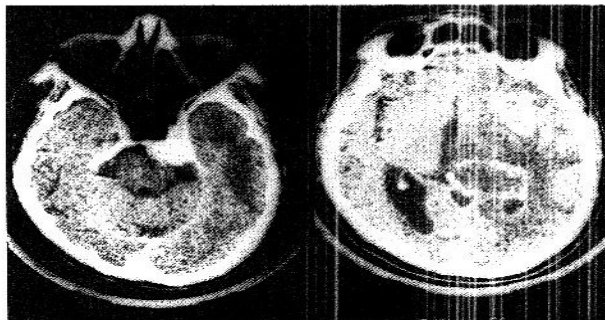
Contrast enhanced CT scan (performed 7 months later with another scanner (sides are inverted) showing besides the lesions already demonstrated in the previous CT scan, another ovoid mass in the left insular region; the retrosellar mass appears to be unchanged
